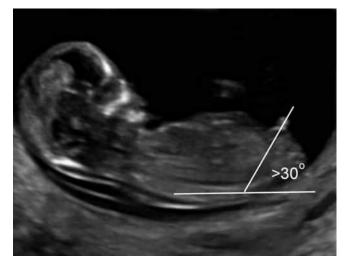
First-trimester transvaginal sonogram shows a male fetus, whose phallus lies at an angle that is ≥30 degrees above the horizontal. The horizontal line aligns with the fetal lumbosacral skin. (Reproduced with permission from Dr. Ashley Zink.)
